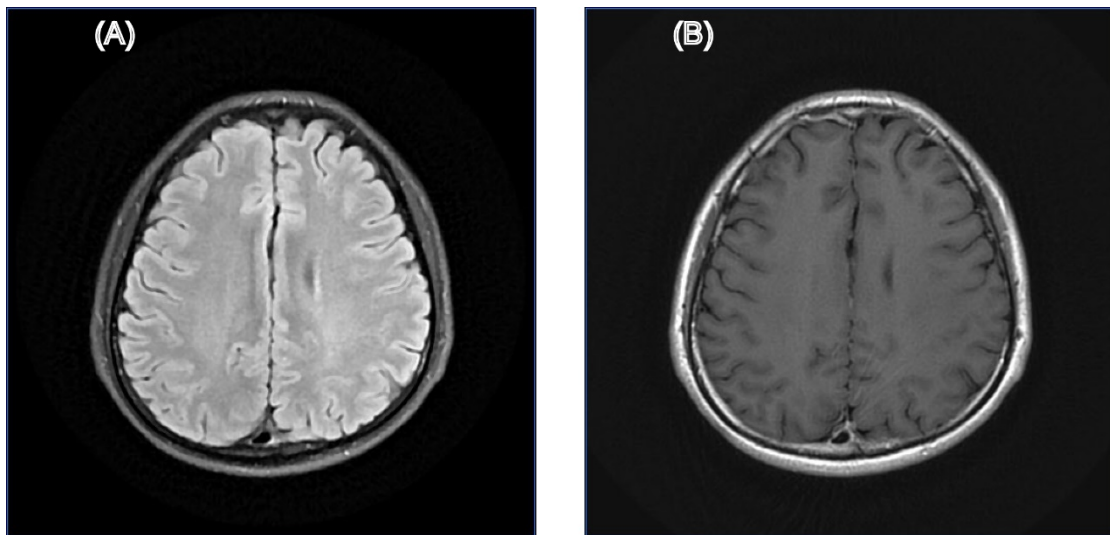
Structural brain MRI images of patient 22. (A) T2-weighted fluid-attenuated inversion recovery (T2-FLAIR) image; (B) Gadolinium-enhanced T1-weighted (Gd-T1w) image.
